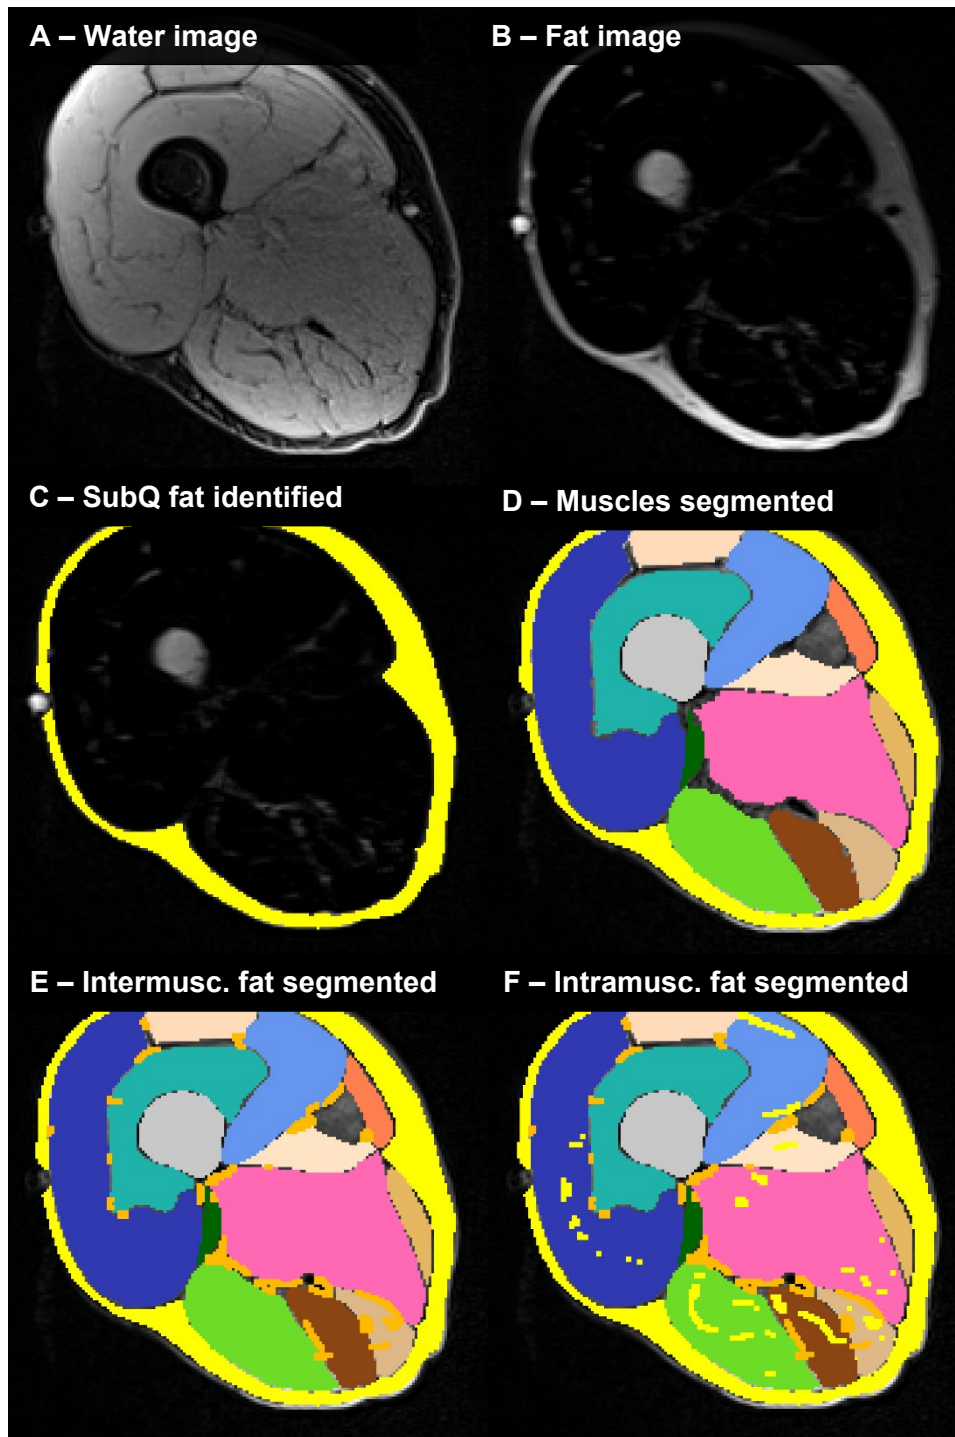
Segmentation of a thigh MR image in ITK-SNAP. Images A and B show the Water and Fat separated images respectively resulting from the Dixon sequence. Image C shows subcutaneous fat segmentation completed, with this layer beginning deep to the skin surface, progressing deep to the superficial fascia lata. Image D shows muscle (and femur) segmentation completed. Image E and F show intermuscular fat and intramuscular fat segmentation completed. The remaining unsegmented space is that of the femoral artery and vein.
